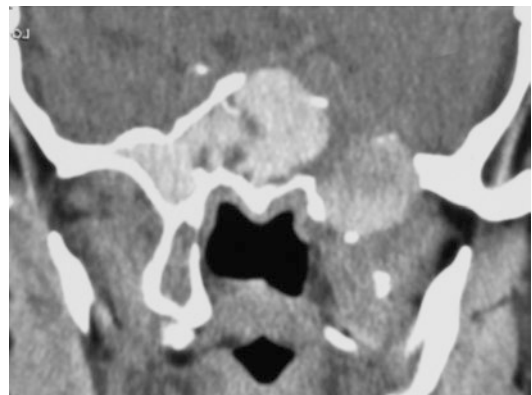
Coronal non-contrast CT image of the sphenoid region in soft tissue windows. There has been expansion of bilateral sphenoid sinuses with hyperdense contents and pronounced bone erosion
